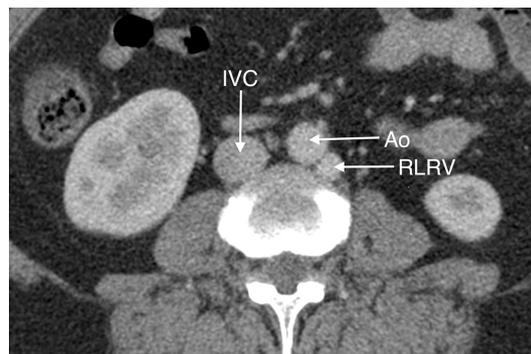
Axial postintravenous contrast CT Image (mixed arterial/venous phase) showing the RLRV coursing left and postero-lateral to the Ao, prior to crossing the midline and draining into the IVC. Ao, abdominal aorta; IVC, inferior vena cava; RLRV, retroaortic left renal vein.
